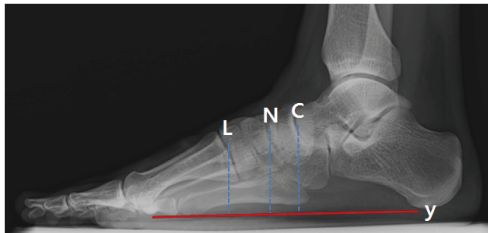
X-ray that is measured medial longitudinal arch.
